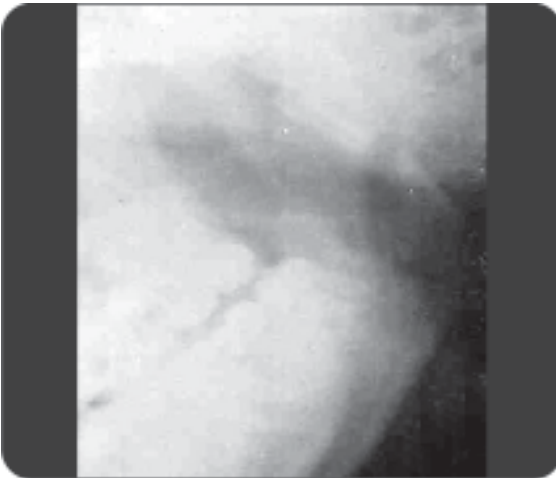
X-ray shows diffuse radiolucency in mandible with multiple radiopacities
